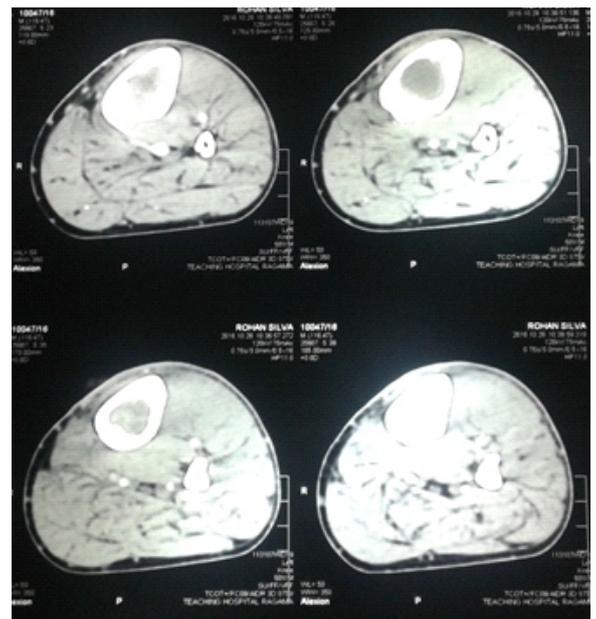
CT appearance of left upper tibia
